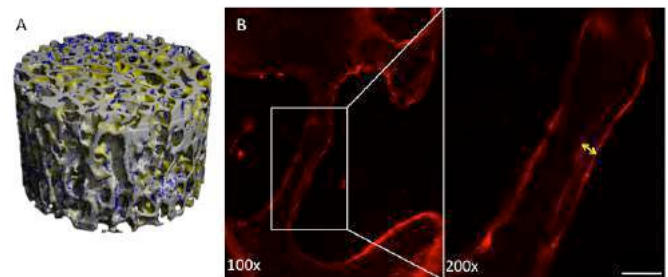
Changes due to bone remodeling were measured using two techniques. (a) Registered μ CT images were compared to identify bone formation (blue) and resorption (yellow) by directly comparing image volumes. (b) Standard dynamic histomorphometry was used to measure bone formation to account for the limited resolution of the μ CT scans. Scale bar represents 50 μ m.
